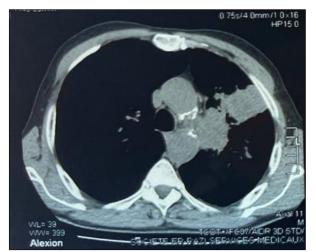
Mediastinal window CT scan of a left upper lobar tissue density mass
